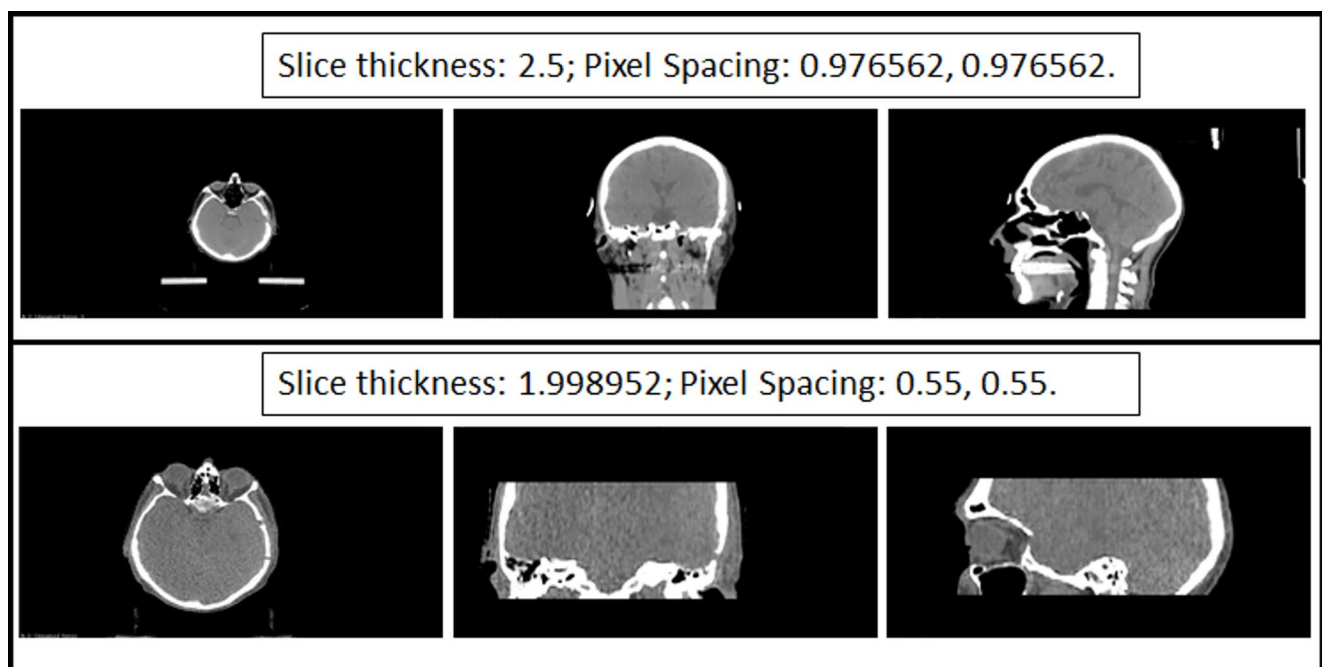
Slides size difference between CT scan and daily kV-CBCT image
